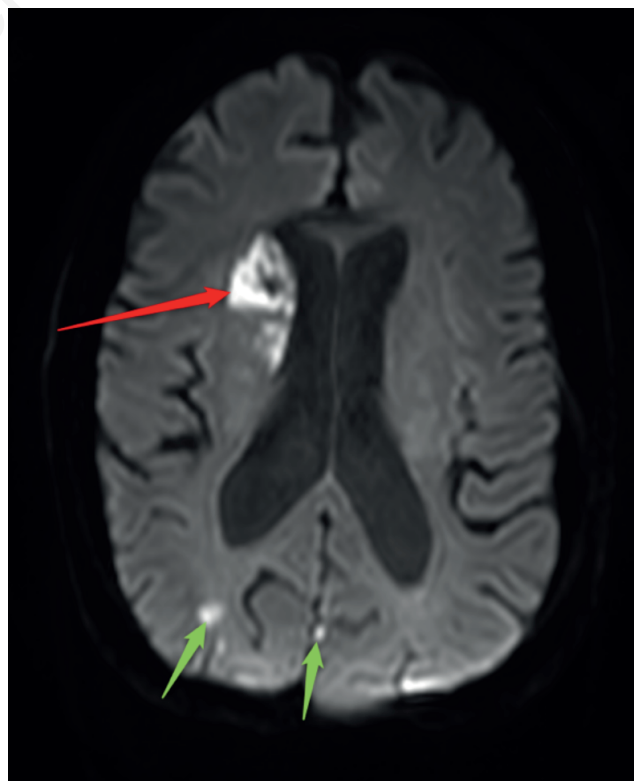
Diffusion-weighted magnetic resonance imaging (axial view), showing the right frontal acute ischemic stroke (red arrows), and other posterior acute ischemic lesions (green arrows).
